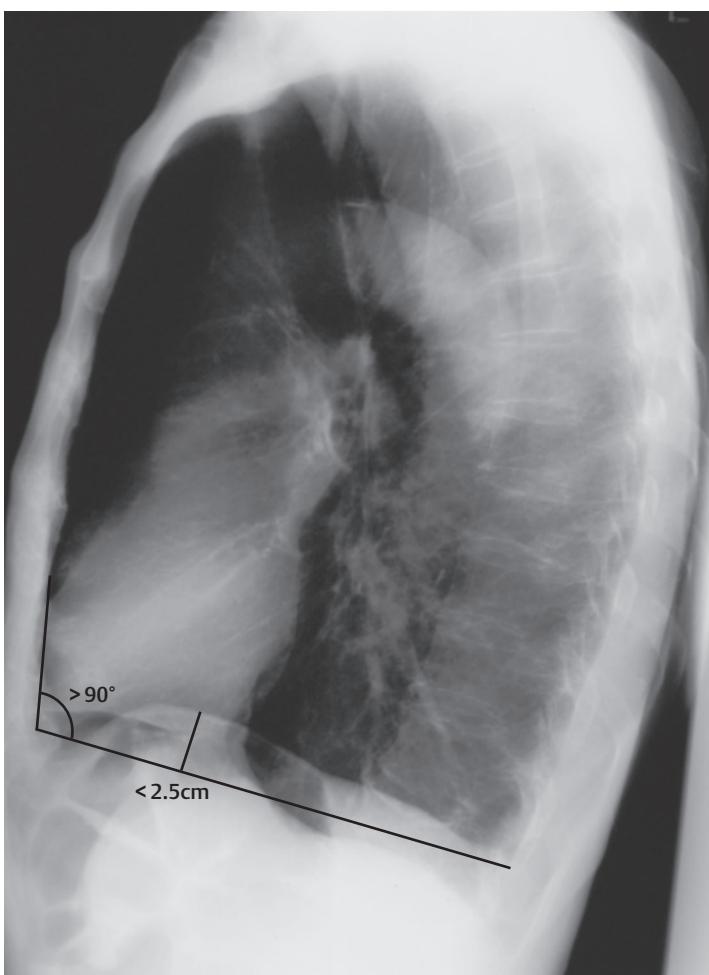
Increased volume in emphysema on the lateral radiograph. Measurements for determining increased chest volume (which is significant in this 73-year-old "pink puffer") have been entered on the radiograph. The dome of the diaphragm is largely flattened. The angle between the sternum and costophrenic recess is increased, and the retrosternal space is enlarged.
